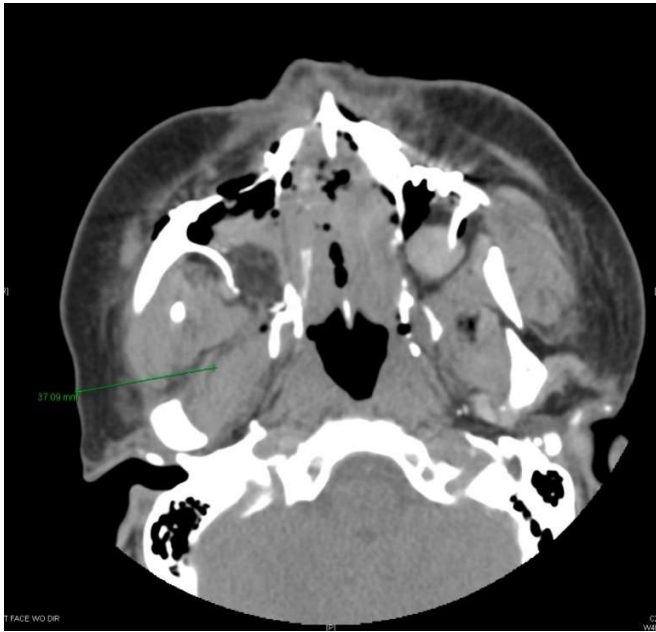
Depth of advancement determined by measuring skin to muscle belly depth on CT.
